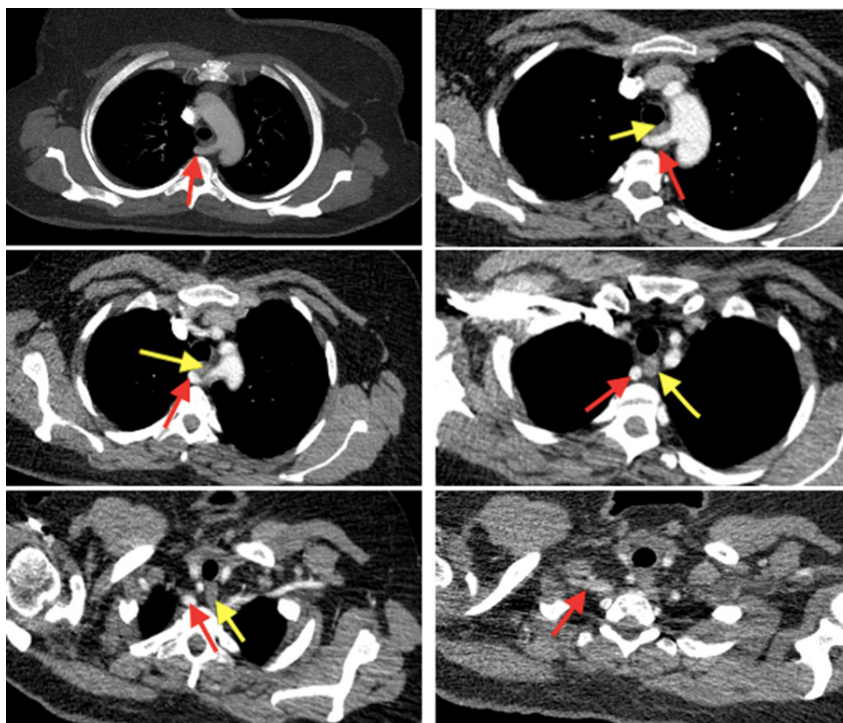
CT scan images of an aberrant right subclavian artery (arteria lusoria) are shown, with the red arrow indicating its origin from the left side as the final branch of the aortic arch. The artery follows a retroesophageal route (yellow arrow: esophagus) to reach its normal position in the arm.
